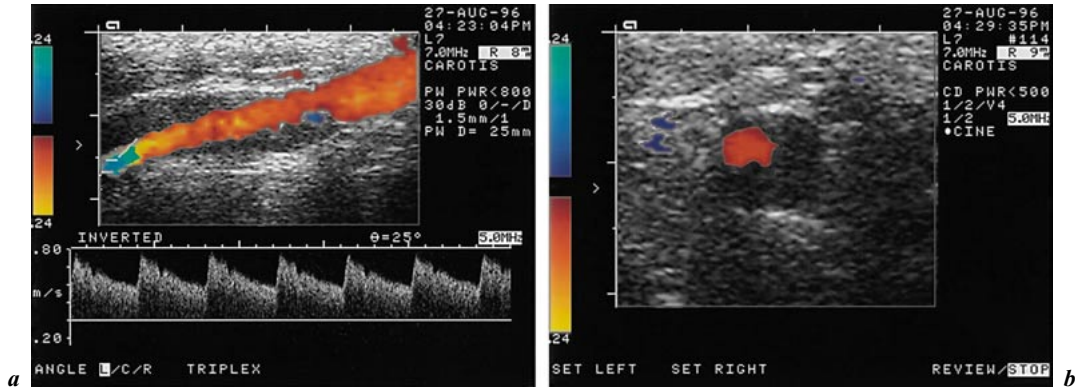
Extracranial color duplex sonography of a spontaneously dissected internal carotid artery shows at longitudinal (a) and (b) axial planes the thickened vessel wall resulting from a hypoechoic mural hematoma, whereas the flow velocities are normal.
